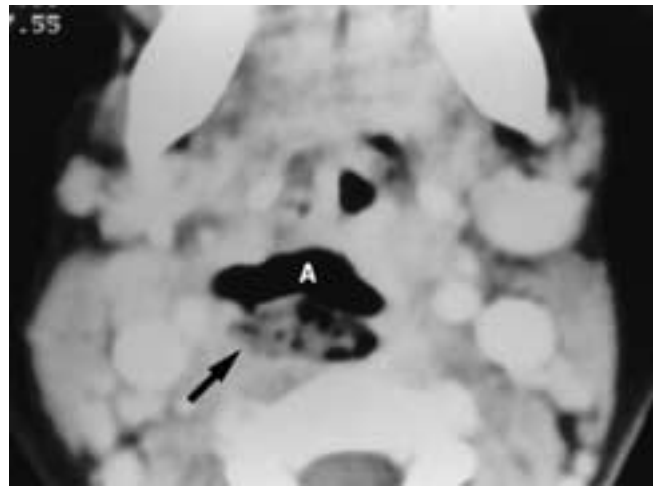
Axial contrast-enhanced CT scan shows a retropharyngeal abscess containing fluid and air (arrow). A, Normal airway of the oropharynx.
